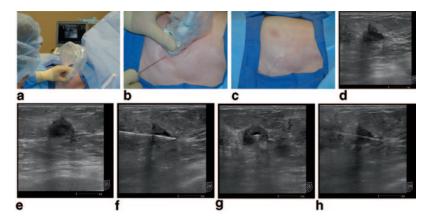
Ultrasound-guided wire localization can be performed in the operating room with numerous advantages to the patient and the surgeon. These figures show
